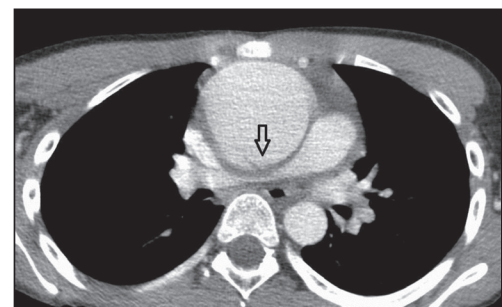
Computed tomography angiography: posterior intimal flap in aneurysmatic ascending aorta
